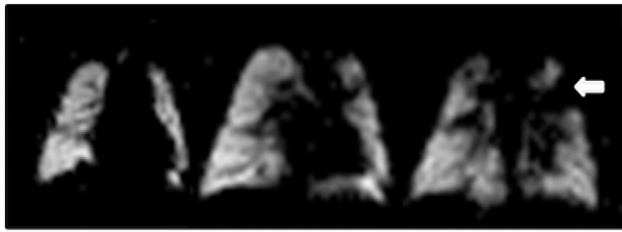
HHe coronal MR images of a 2-month-old premature infant. A focal ventilation defect is present in the left upper lobe (arrow). Other smaller defects are also present. For this patient, HHe gas was administered via the medication port on a pediatric bag valve mask.
